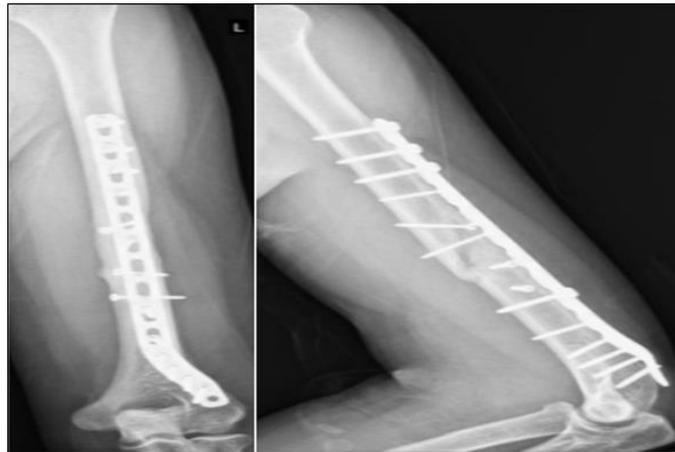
Immediate post-operative of anteroposterior and lateral radiographs with extra articular distal humerus locking plate and inter-fragmentary screws showing inadequate reduction and end to end contact of fragments with gap in cortex opposite to the plate
